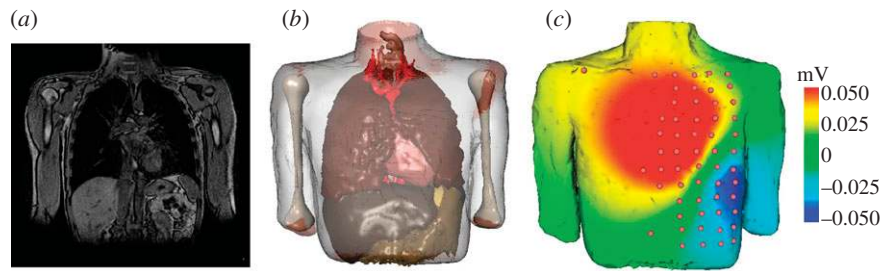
Segmentation of a volunteer dataset. (a) MRI slice from the thorax; (b) three-dimensional visualization of the segmented thorax; (c) interpolation of BSPM onto the thorax mesh.
